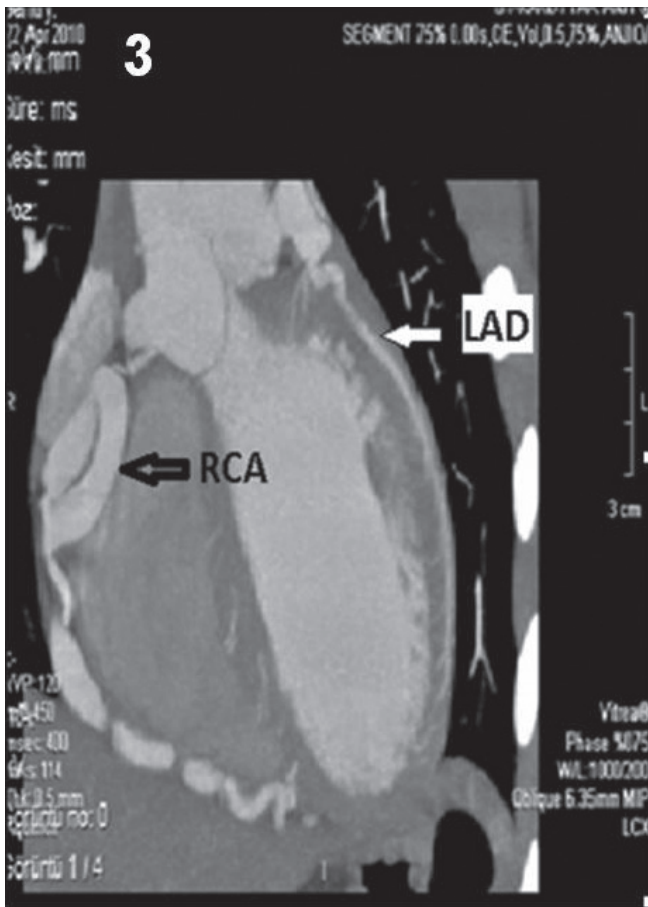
Longitudinal image with CT angiography showing the right coronary artery originating from the aorta, and the LAD originating from the pulmonary artery. RCA: right coronary artery, LAD: left anterior descending artery.
